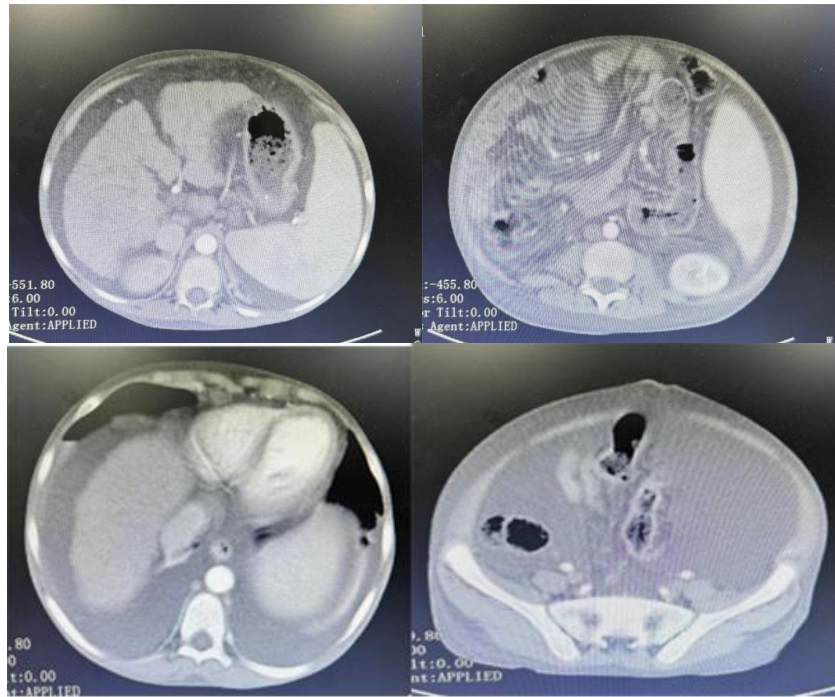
CT of Patient with Ascites.
